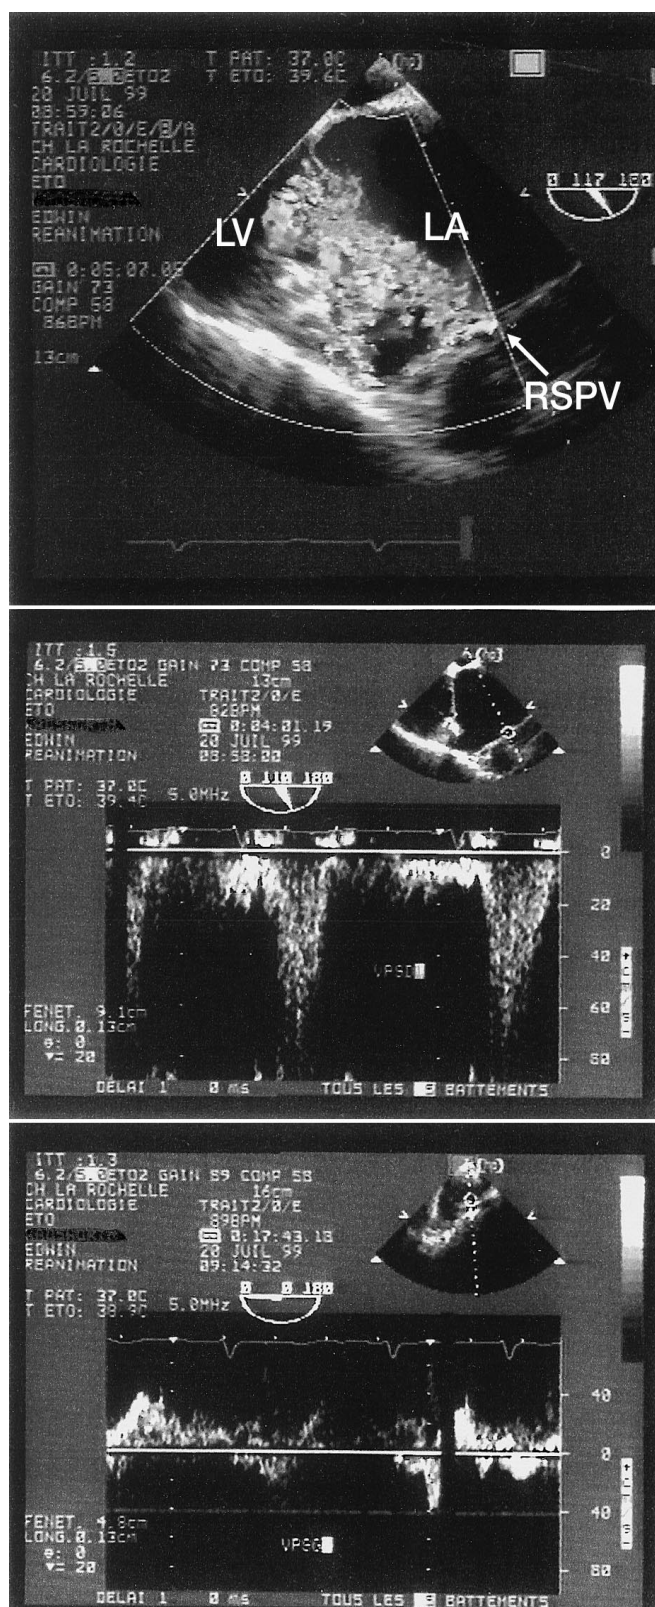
Transgastric incidence by colour Doppler (*upper portion of the panel*) in case 3 showing the regurgitant jet directed to the RSPV. *Middle portion*: pulsed Doppler demonstrating the systolic reversal of flow in the RSPV. *Lower portion*: normal flow (transoesophageal incidence) in the LSPV (LA left atrium, LV left ventricle, RSPV right superior pulmonary vein, LSPV left superior pulmonary vein)
